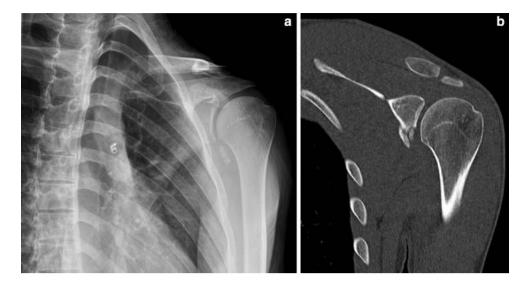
Preoperative anteroposterior, a radiograph and coronal, b CT images of the left shoulder demonstrating a bony Bankart lesion with a fragment of bone in the axilla as well as glenoid bone loss involving 25 % of the glenoid surface, a Hill-Sachs lesion, and an inferior loose body
